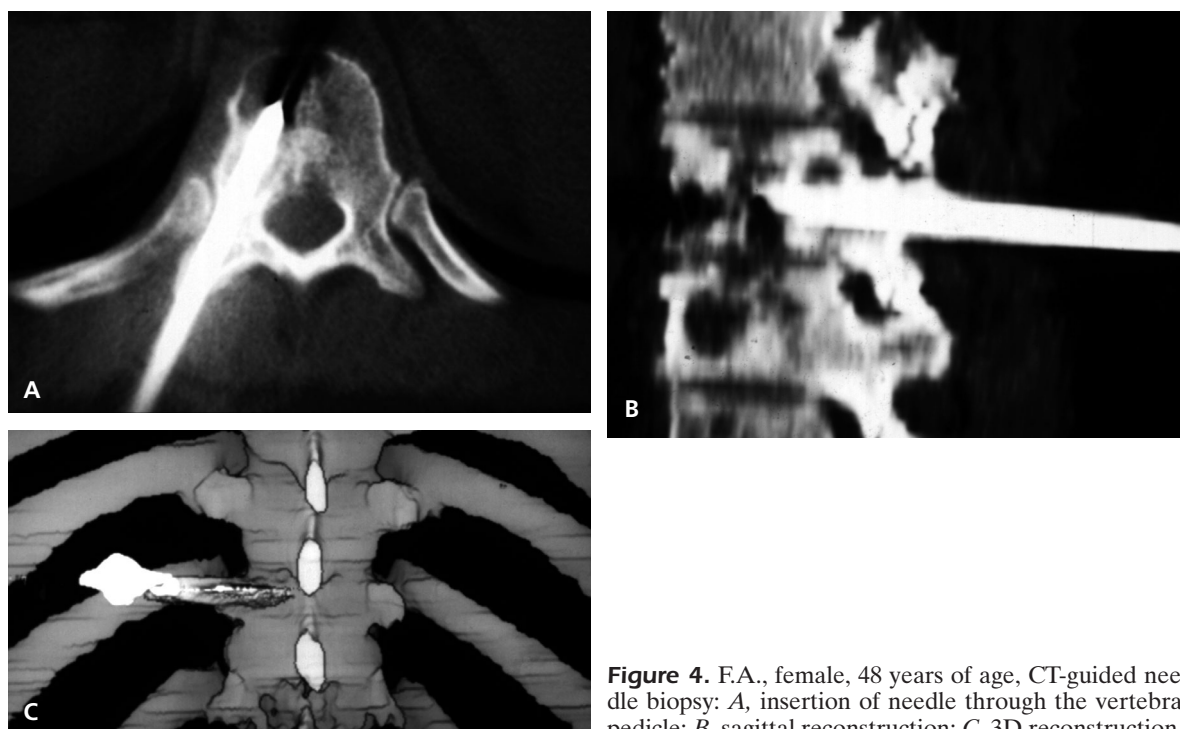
F.A., female, 48 years of age, CT-guided needle biopsy: *A*, insertion of needle through the vertebral pedicle; *B*, sagittal reconstruction; *C*, 3D reconstruction.
